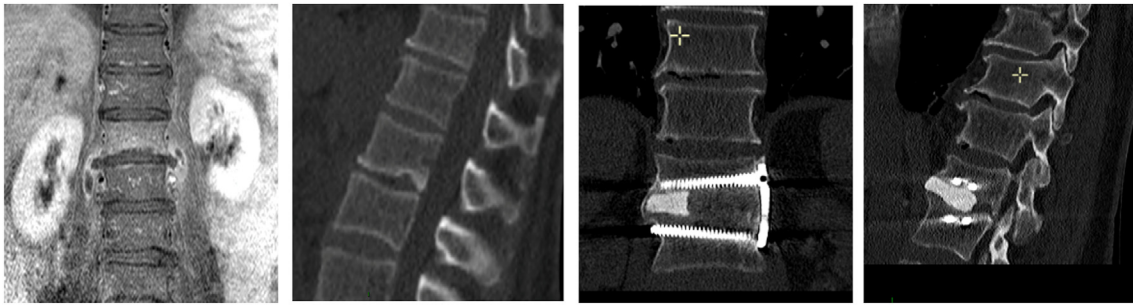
81 y old man hospitalized for L1-L2 spondylodiscitis. MSSA was identified on blood culture. Early surgery was indicated here because of untractable pain (a rare indication). Goal was to speed up recovery in this frail patient. Limited lumbotomy, debridement and reconstruction with cement and grafts. Gap height was 12 mm. Pain stopped after surgery, allowed to walk without any brace. Patient was discharged one week after surgery. On the right side, CT scan at 5 years postop, showing fusion and good tolerance of the PMMA cement.
